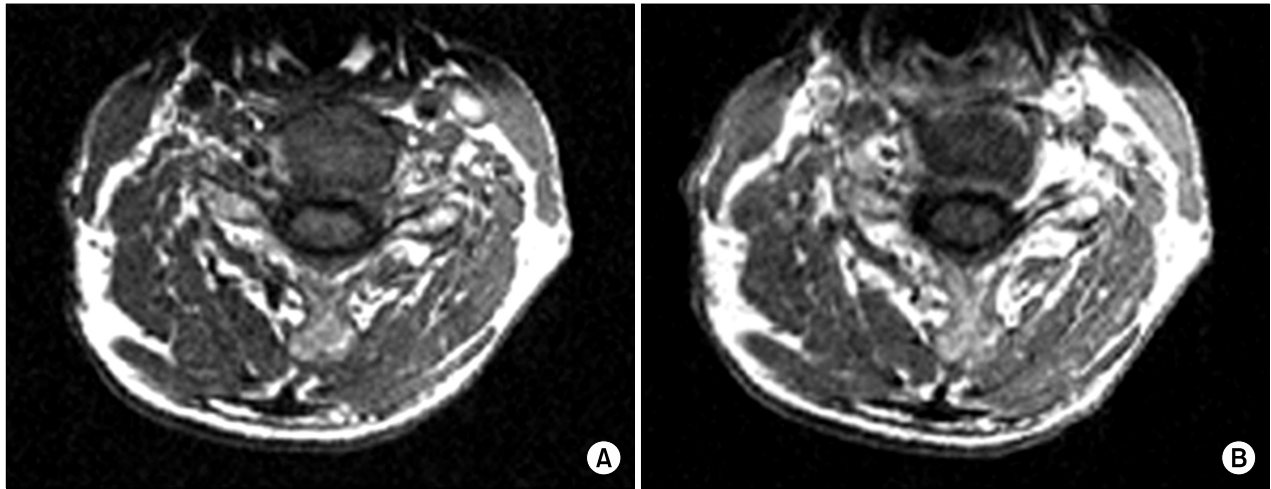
Magnetic resonance imaging findings demonstrating a swelling and enhancement in the 6th and 7th cervical nerve roots. (A) T1 weighted axial imaging. (B) Gadolinium enhanced T1 weighted axial imaging.
